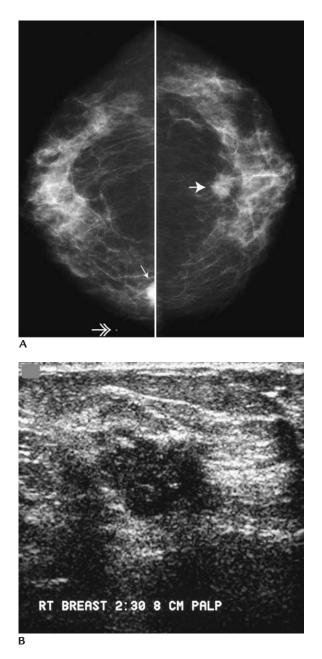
Invasive ductal carcinoma, bilateral synchronous lesions. (A) Craniocaudal views in a patient presenting with a palpable mass in the right breast. Metallic BB (*double headed arrow*) used to mark area of clinical concern. A mass (*small arrow*) is partially seen posteromedially at the edge of the right craniocaudal view. Although multiple images were attempted, because of its location in the upper inner quadrant of the right breast, it could not be seen in entirety mammo-graphically. A clinically occult spiculated mass (*larger arrow*) is noted in the left breast. Remember to not let yourself be distracted by the clinical finding; evaluate the mammogram completely before focusing in on obvious findings. (B) An irregular hypoechoic mass with indistinct, spiculated, and angular margins is imaged in the upper inner quadrant of the right breast. Ultrasound is helpful in evaluating areas that may otherwise be difficult to image mammographically (e.g., axillary tail, far posterolateral lesions, upper inner quadrant close to the chest wall).
